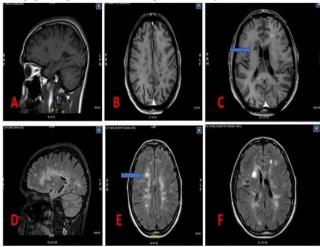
Shows Multiple discrete ovoid T2 - FLAIR hyperintense lesions are seen in both supra as well as infratentorial brain parenchyma (Figs 2D, 2E &2F). These are seen in bilateral periventricular white matter involving the corpus callosum, bilateral fornto-parieto-temporal juxtacortical white matter mores on in the both temporal lobes, bilateral internal capsules, cerebral peduncles, as well as deep white matter of cerebellum. Few of these lesions in the right frontal periventricular white matter show incomplete rim of enhancement (Fig 2C).
